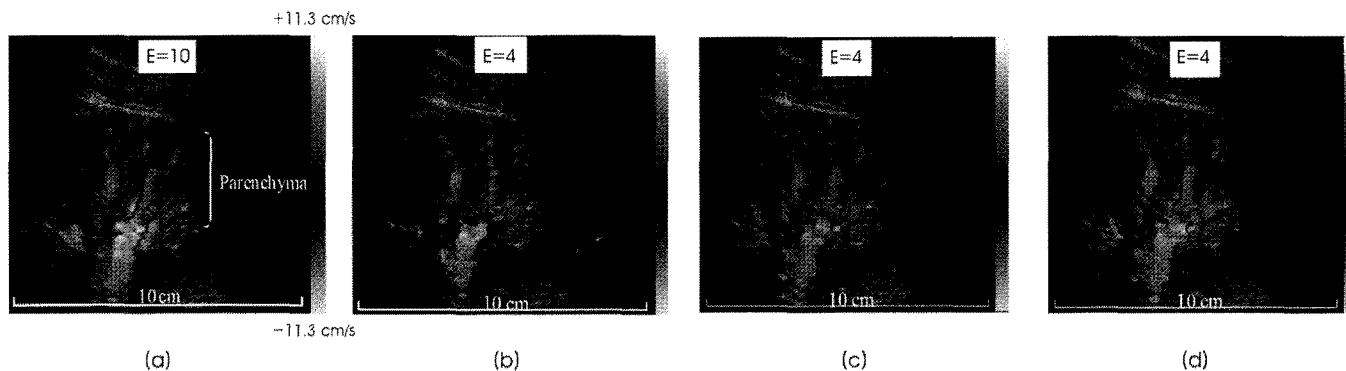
Color Doppler images obtained from the kidney by applying (a) AC-ACR with E=10 as the reference, (b) AR, (c) ED, and (d) AC-ACR methods.
